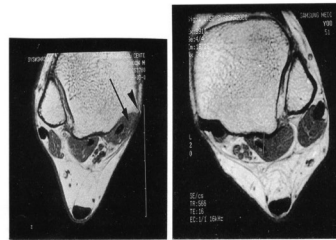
Foot MRI demonstrated non-visualization of posterior tibial tendon(✓), medial malleolar spur(↖) on the right side and normal findings on the left side.
